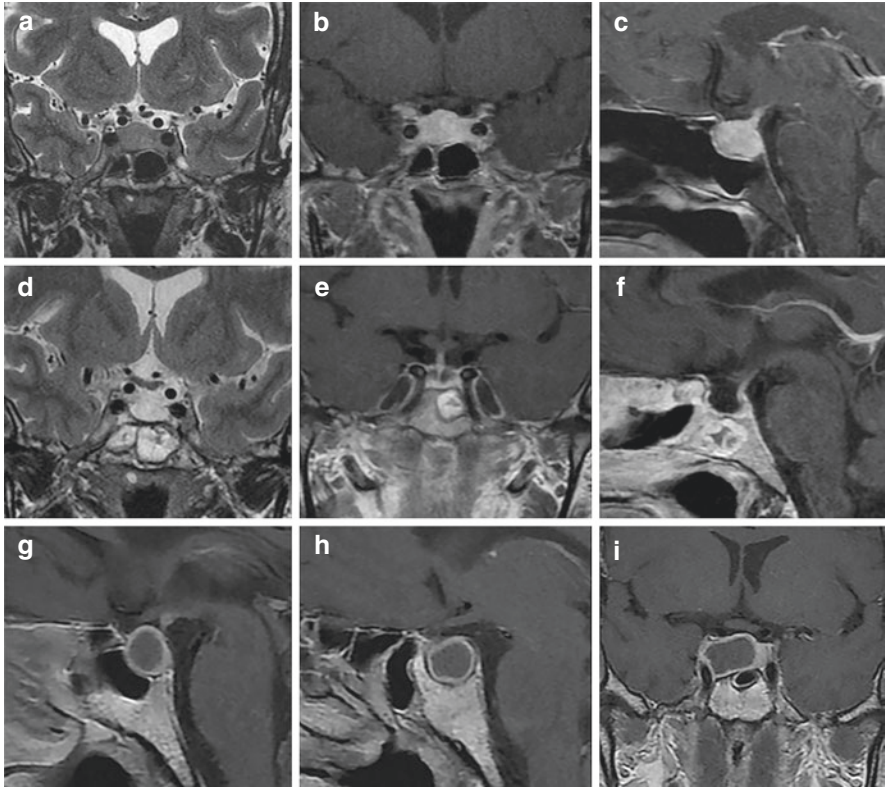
Tuberculous hypophysitis and tuberculous pituitary abscess. Pre- (a–c) and postoperative (d–f) MR images in one case of tuberculous hypophysitis that was treated by endoscopic endonasal transsellar approach. (g–i) Preoperative MR images in another patient with pituitary tuberculous abscess
